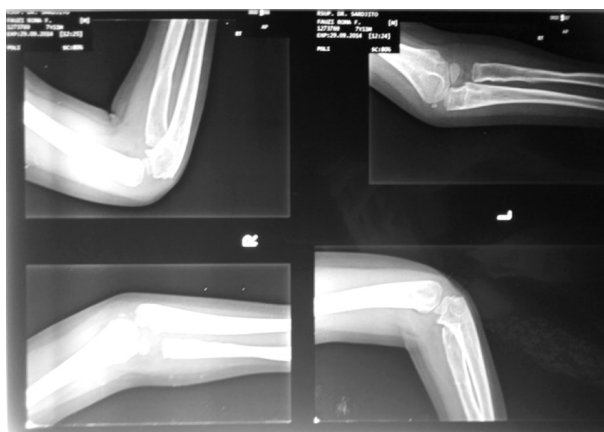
X-rays of the elbow joint
